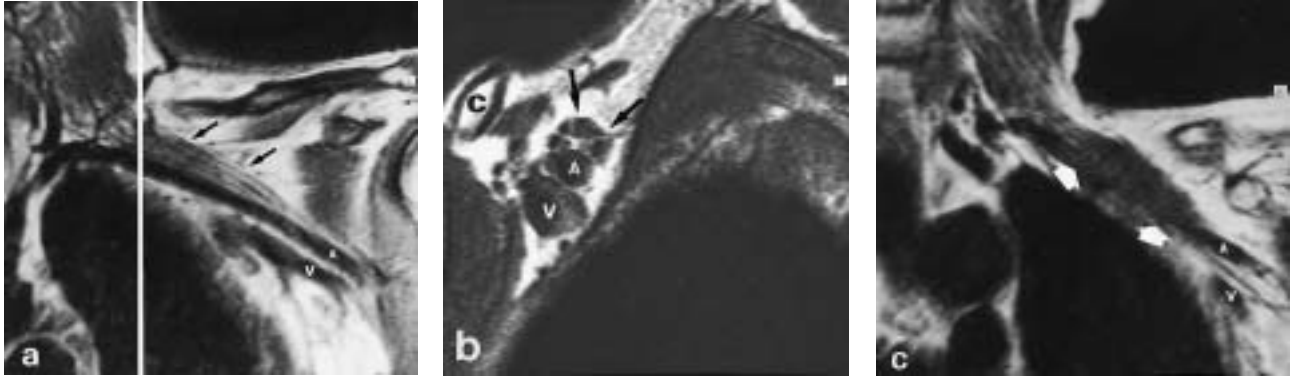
High-resolution anatomical magnetic resonance (MR) visualization of the brachial plexus. a) Oblique coronal T1-weighted MR image with typical appearance of the band-shaped fascicles of the brachial plexus (arrows) extending superiorly to the (left) subclavian artery (A) (V: subclavian vein). b) Cross-sectional sagittal view (according to the white line in (a)); behind the clavicle (C) the low-signal fascicles of the brachial plexus (arrows) are easily appreciable within the fat superior to the subclavian artery (A) and vein (V). c) Tumour invasion of the brachial plexus. Oblique coronal T1-weighted MR image shows low-signal tumour tissue of the metastatic breast cancer invading the fascicles of the plexus (arrows) and presumably involving the adjacent left subclavian artery (A).
